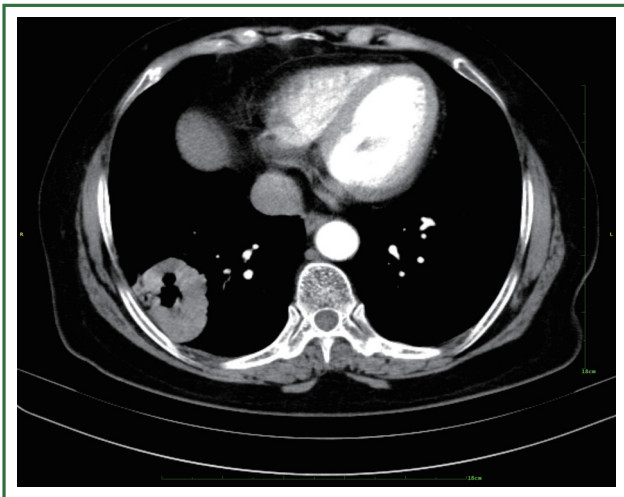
Axial contrast-enhanced chest CT shows a right lower lobe lesion on mediastinal window.
